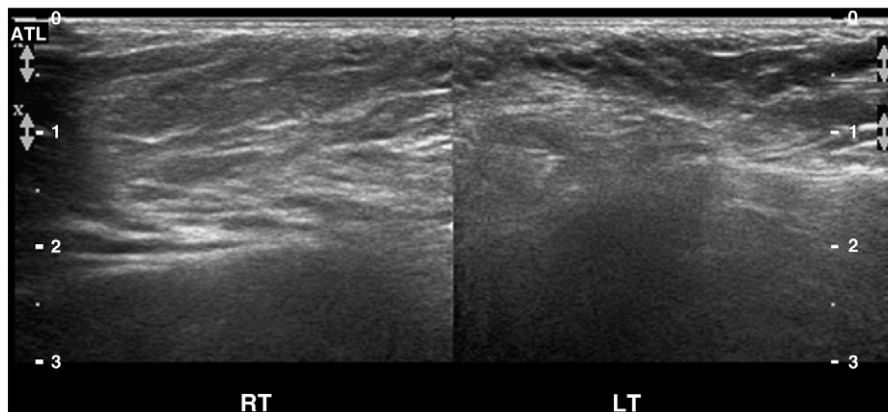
Ultrasonography (case 5) showing a diffusely increased echogenicity of subcutaneous fat in the right labium major (RT) in comparison to the contralateral region of the left labium major (LT).
